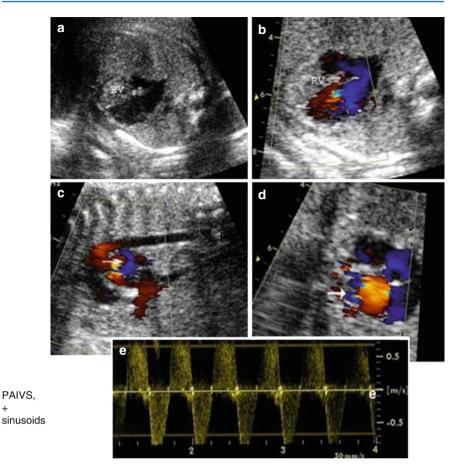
Case of PAIVS and hypoplastic RV (\mathbf{a} , \mathbf{b}), reversed flow from the duct (\mathbf{c}), and turbulent flow at color Doppler due to sinusoids (\mathbf{d}), with systodiastolic flow at pulsed Doppler (\mathbf{e})
